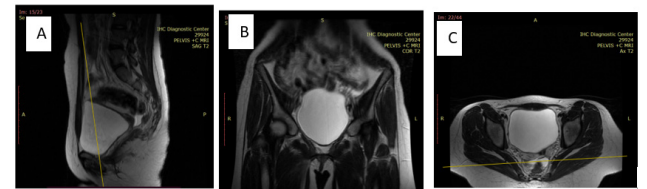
Magnetic resonance of pelvis. A) sagittal, B) coronal, and C) axial T2-weighted images show the absence of the uterus and vagina. Also, the presence of free fluid in the pelvis.
